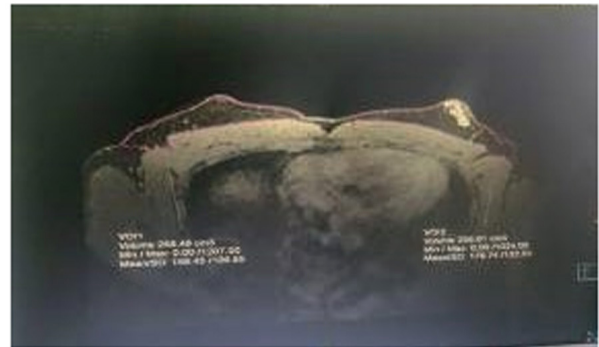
MRI showing hyperenhanced lesion in the left breast
